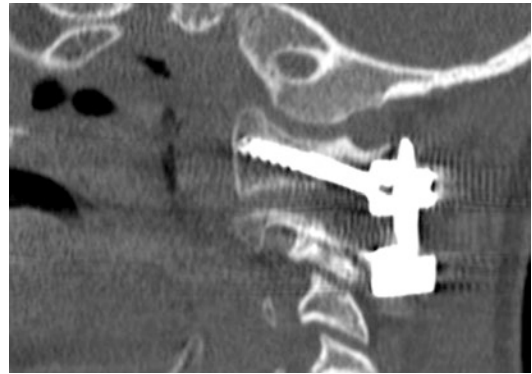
Sagittal CT cut of a patient who had undergone C1-C2 instrumentation. Note the position of the C1 screw underneath the C1 arch, the partially threaded screw used to avoid C2 nerve irritation, and the distance of the tulip from the screw entry point
